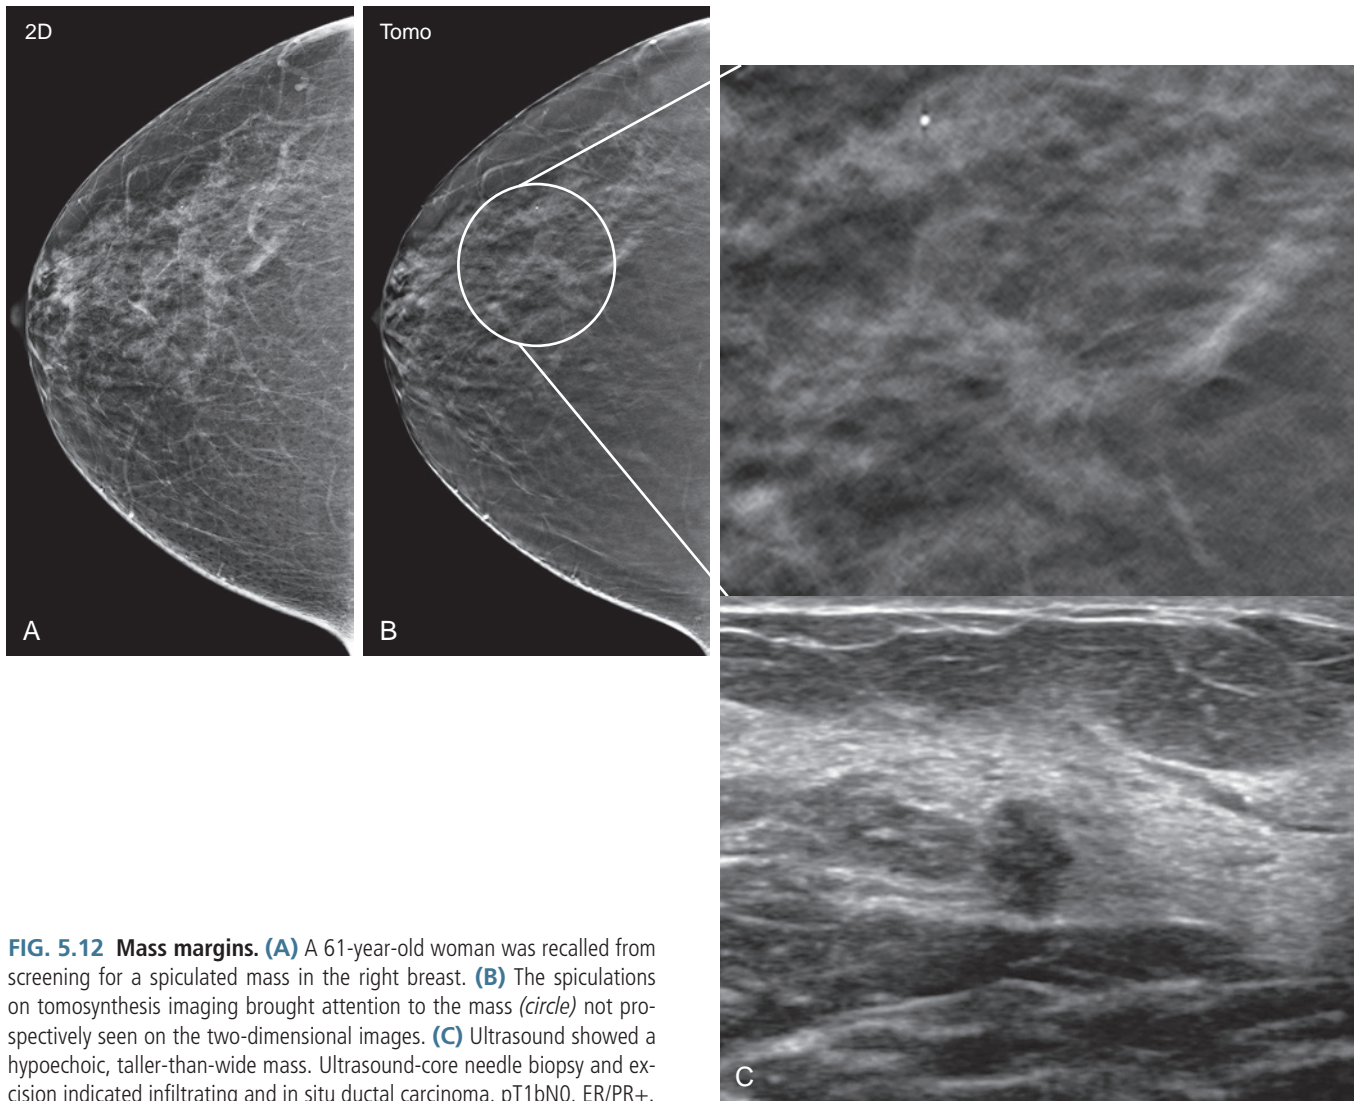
Mass margins. (A) A 61-year-old woman was recalled from screening for a spiculated mass in the right breast. (B) The spiculations on tomosynthesis imaging brought attention to the mass (*circle*) not prospectively seen on the two-dimensional images. (C) Ultrasound showed a hypoechoic, taller-than-wide mass. Ultrasound-core needle biopsy and excision indicated infiltrating and in situ ductal carcinoma, pT1bN0, ER/PR+.
